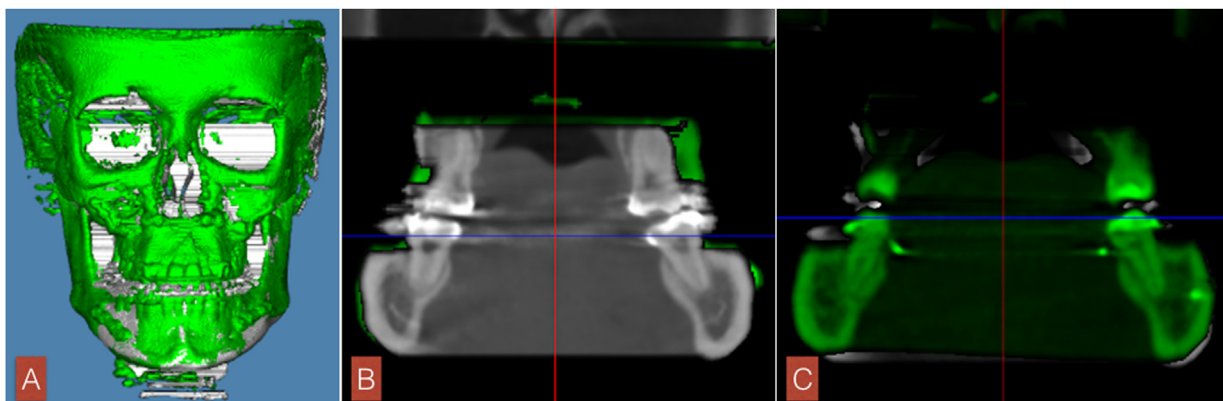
(A) Superimposition of the preoperative and postoperative CBCT scans. (B) Preoperative image of the IAC on coronal view at a specified point. (C) Postoperative image of the IAC on coronal view at the same specified point. The gray color represents the preoperative image, whilst the green color represents the postoperative image. (CBCT, cone beam computed tomography; IAC, inferior alveolar canal.)
